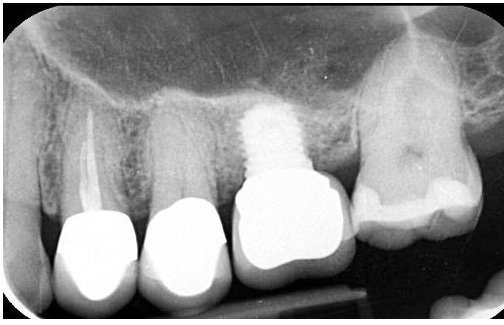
Radiograph at 8 years: stable implant with apex surrounded by mature bone with a corticalized boundary of the grafted compartment.
